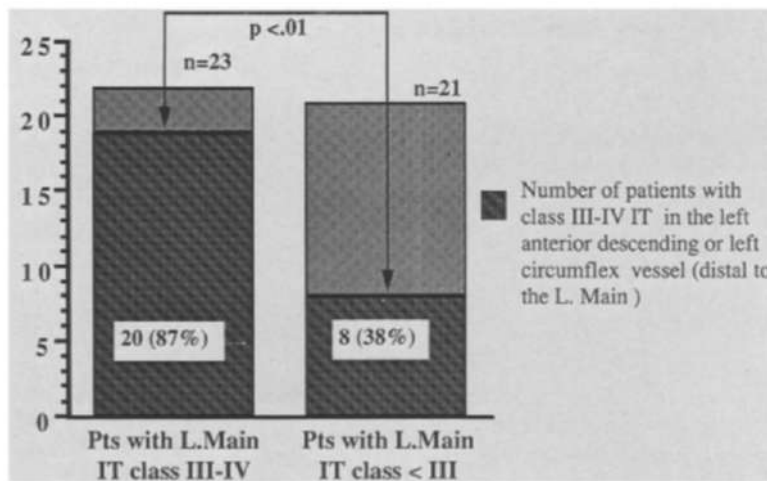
Comparison of more distal disease with left main (*L.Main*) disease in 44 patients with appropriate imaging sites for analysis. *Left bar* shows intracoronary ultrasound findings in more distal vessels in 23 patients with significant intimal thickening (*IT*) in left main coronary artery. *Right bar* shows incidence of finding more distal in 21 patients without significant intimal thickening in left main vessel.
